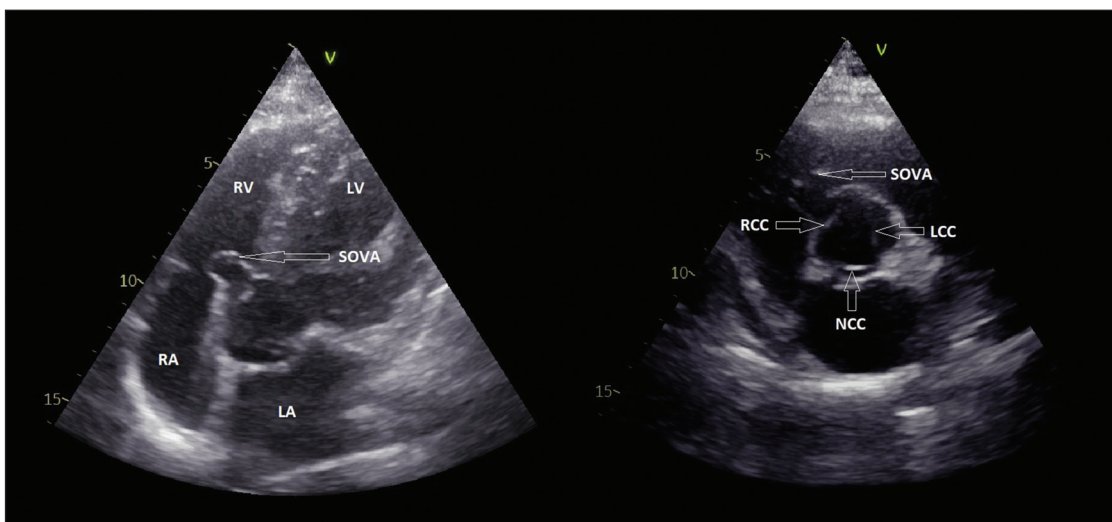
Transthoracic echocardiography (TTE). Left side: apical-5-chamber plane (A5C). Right side: parasternal short axis plane (PSAX). LA – left atrium; LCC – left coronary cusp; LV – left ventricle; NCC – noncoronary cusp; RA – right atrium; RCC – right coronary cusp; RV – right ventricle; SOVA – sinus of Valsalva aneurysm.
